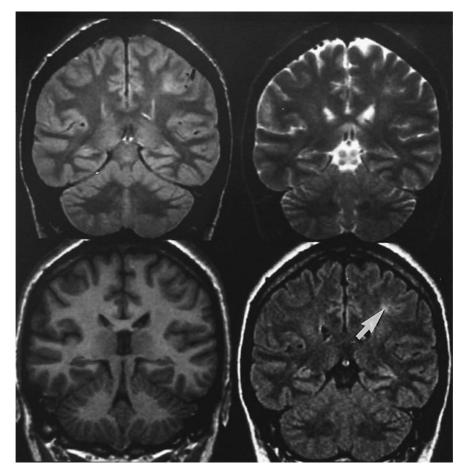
Coronal MRI of focal area of dysgenesis in region of left central sulcus. Four images from the same plane: *upper left*, proton density (TE 30); *upper right*, T₂-weighted (TE 120); *lower left*, T₁-weighted (IF SPGR); *lower right*, FLAIR. The abnormality is apparent on the proton density and T₂-weighted images, but is more conspicuous on the FLAIR image (arrow).
